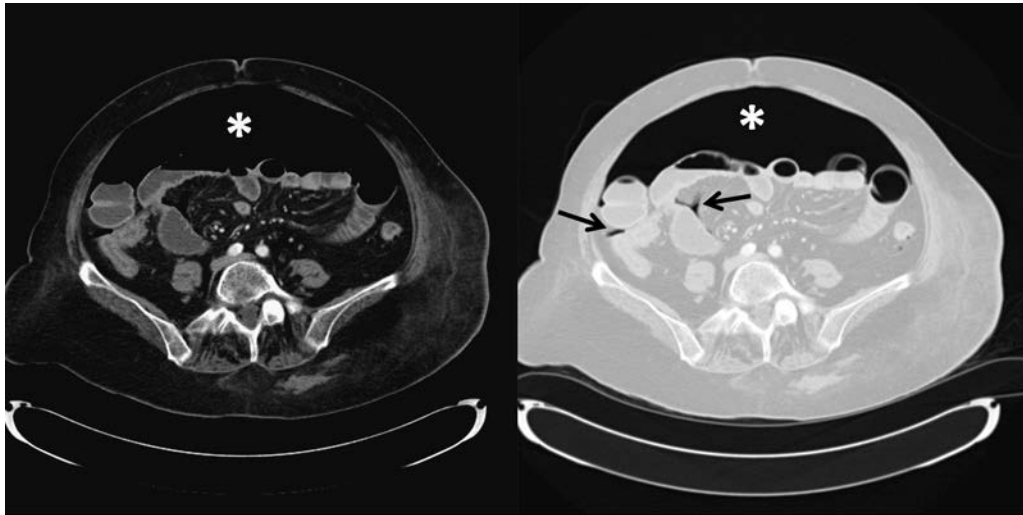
Axial section of CT scan at level of aortic bifurcation in a patient with iatrogenic gastric perforation. Massive pneumoperitoneum with free intraperitoneal air (*) seen between the anterior abdominal wall anteriorly and the bowel loops posteriorly. The free gas is better seen on lung windows (image on the right, *) with locules of inter-bowel loop gas (arrows).
